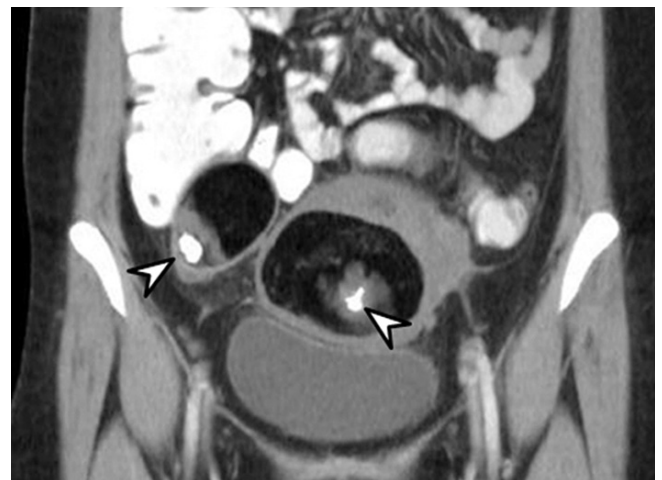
Mature cystic teratomas in 40-year-old female. On coronal contrast-enhanced CT image, bilateral ovarian fatty masses containing punctate calcification (arrowheads) are visible. These are pathognomonic radiologic findings of mature cystic teratoma.
